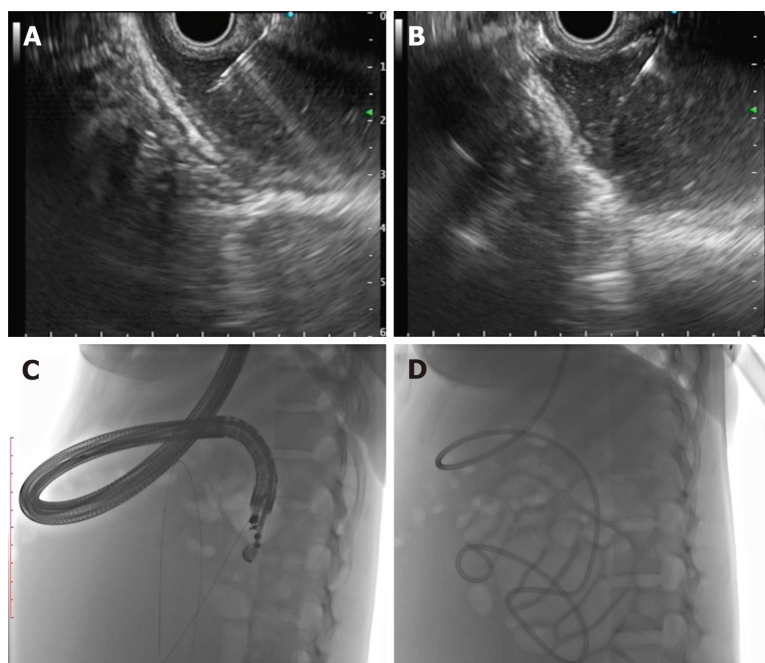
Endoscopic ultrasound-guided internal drainage of loculated ascites. A: Puncture of the loculated ascites with 19-G aspiration needle; B: Guidewire negotiated across as visualized on endoscopic ultrasound; C: Fluoroscopic view of guidewire coiled inside the loculated ascites; D: Naso-cystic drain placed inside the loculated ascites.
